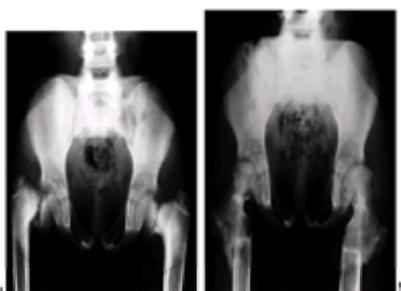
The anteroposterior pelvic radiographs of a boy 6 years, 3 months of age demonstrates bilateral developmental coxa vara. A: Preoperative radiograph. B: The postoperative radiograph, 8 months after the subtrochanteric proximal femoral derotational osteotomies, demonstrates bilateral spontaneous closure of the proximal femoral epiphyseal plates, and the greater trochanteric apophyses remain open. (From ref. 34, with permission.)
